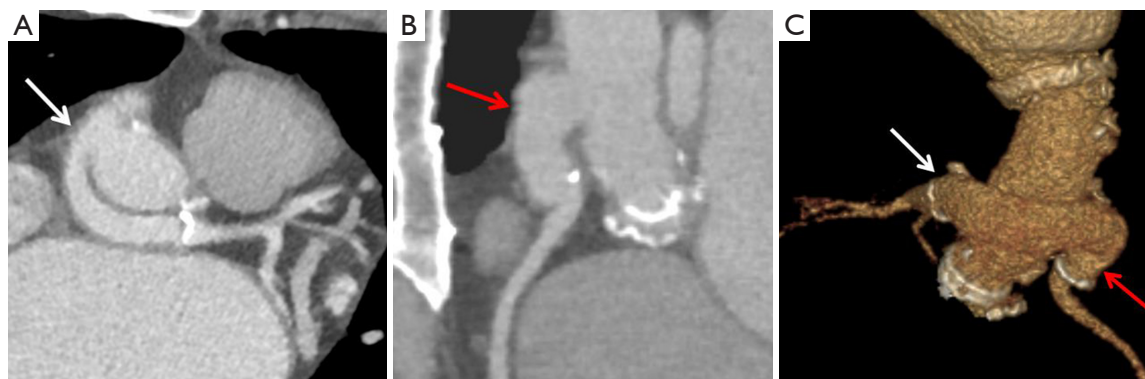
Post-operative imaging of Cabrol procedure in a 44-year-old man. Axial CT angiogram shows a patent left coronary limb [white arrows in (A,C)] and patent right coronary limb [red arrows in (B,C)].
